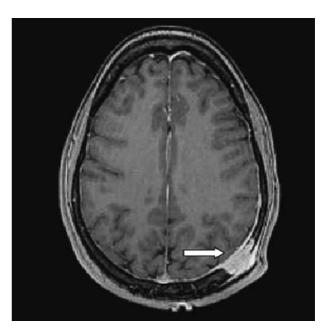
MRI (T1 post contrast) shows a bright lesion involving the posterior parietal skull and the adjacent tissue (arrow).
